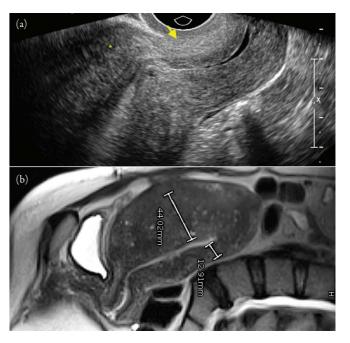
(a) Adenomyosis on transvaginal ultrasound. Note the enlarged uterus, asymmetric thickening (*) and heterogeneous appearance (arrow) of the anterior myometrium. Image courtesy of Shaden Mohammad, MD, and Monica Deshmukh, MD, Department of Radiology, Olive View–UCLA Medical Center, Los Angeles, CA. (b) Adenomyosis on T2-weighted magnetic resonance imaging of the pelvis. On this long axis view of the uterus, note the asymmetric thickening of the anterior myometrium, as well as the micro-cysts and heterogeneous signals from the myometrium.
